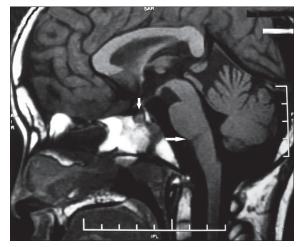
MRI brain (T1) showing absent bright spot of posterior pituitary (small arrow) and brainstem atrophy (big arrow)
